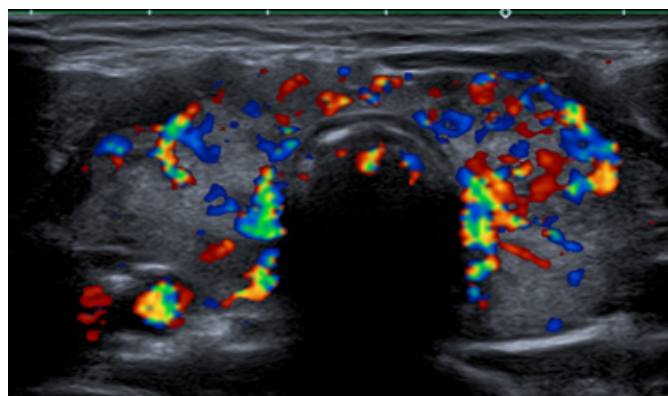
Color Doppler image showing markedly increased diffuse parenchymal vascularity, the "thyroid inferno" pattern characteristic of Graves' disease.
